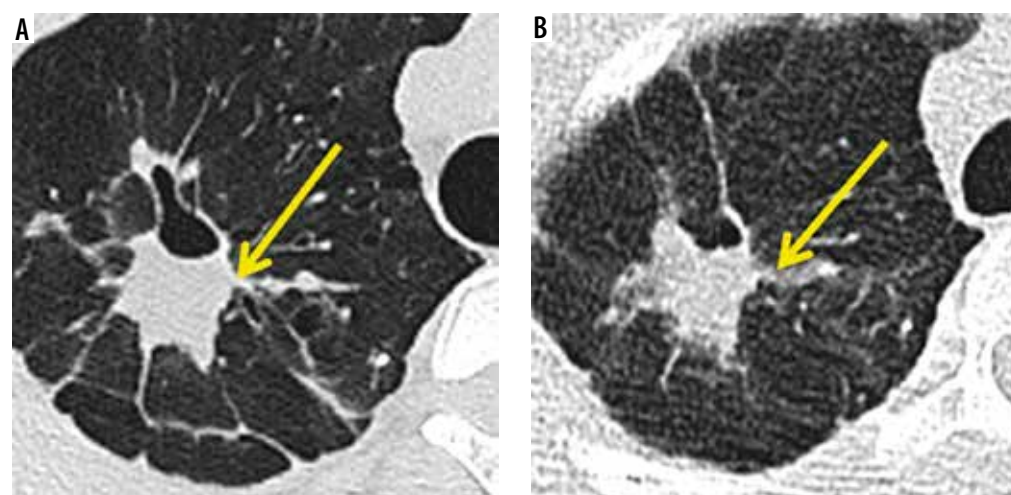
Axial sections of computed tomography (CT) showing detectability of consolidation (yellow arrow) by both standard ultra-low dose CT
